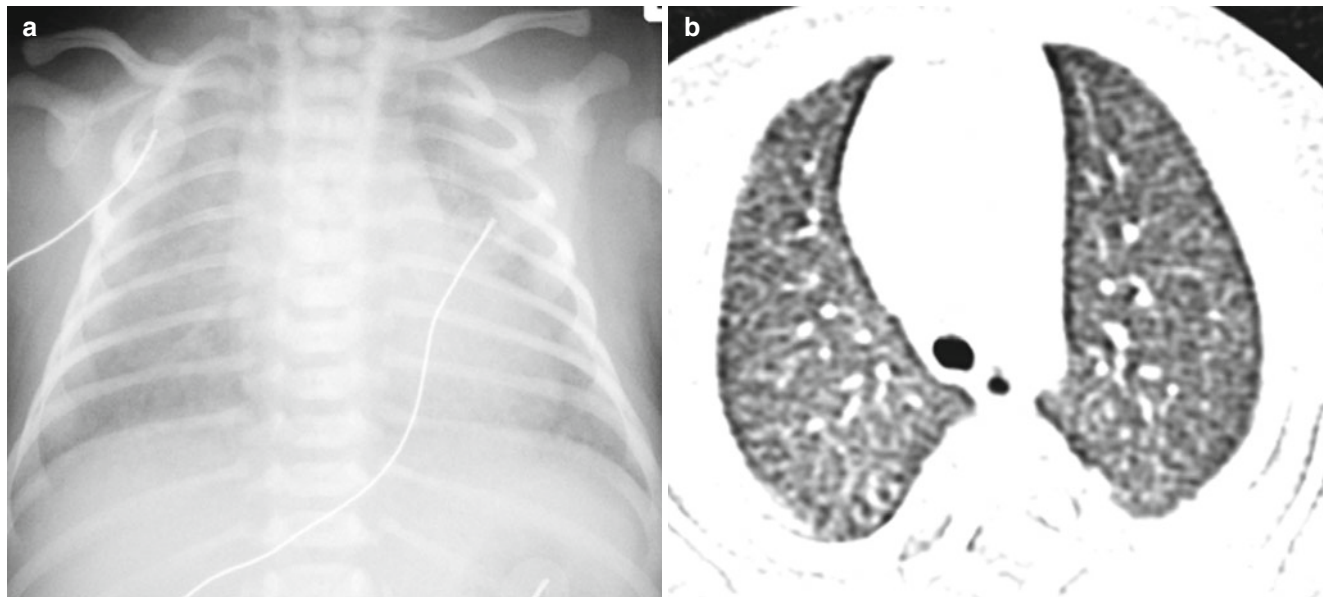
Surfactant protein B mutation in a full-term newborn boy. (a) Frontal chest radiograph shows diffuse hazy granular opacity resembling respiratory distress syndrome of prematurity. (b) Axial lung window CT image demonstrates diffuse ground-glass pulmonary opacification
